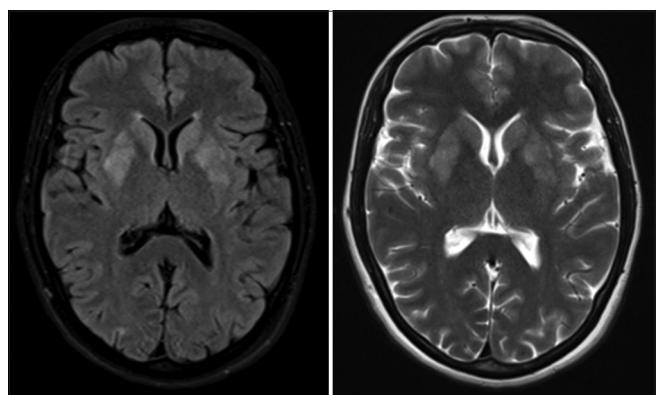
T2 and FLAIR hyperintensities in bilateral caudate and lentiform nuclei
